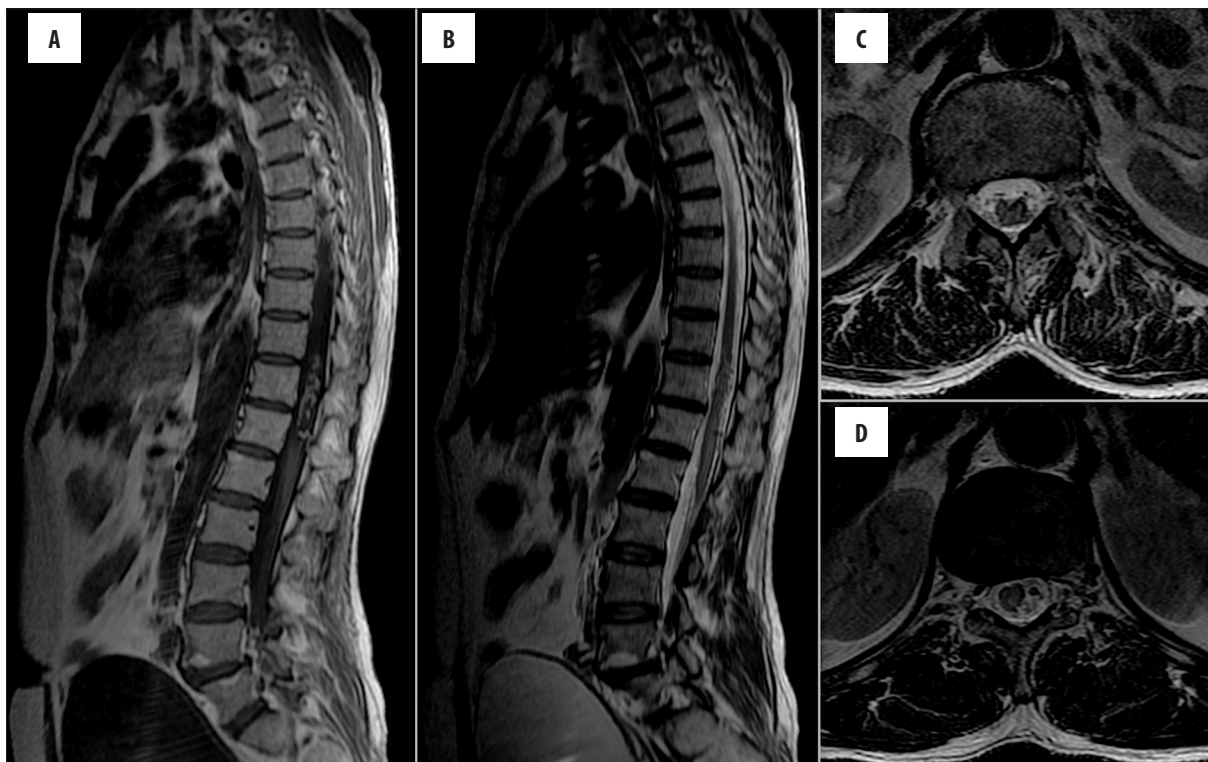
MR performed eight months after the procedure. Sagittal T1-weighted (A) and T2-weighted (B), as well as axial T2-weighted (C, D) images show thrombosed AVM (arrow in A) with irregular outline of the lower cord and conus, reduced bulk and altered signal suggesting gliotic changes.
